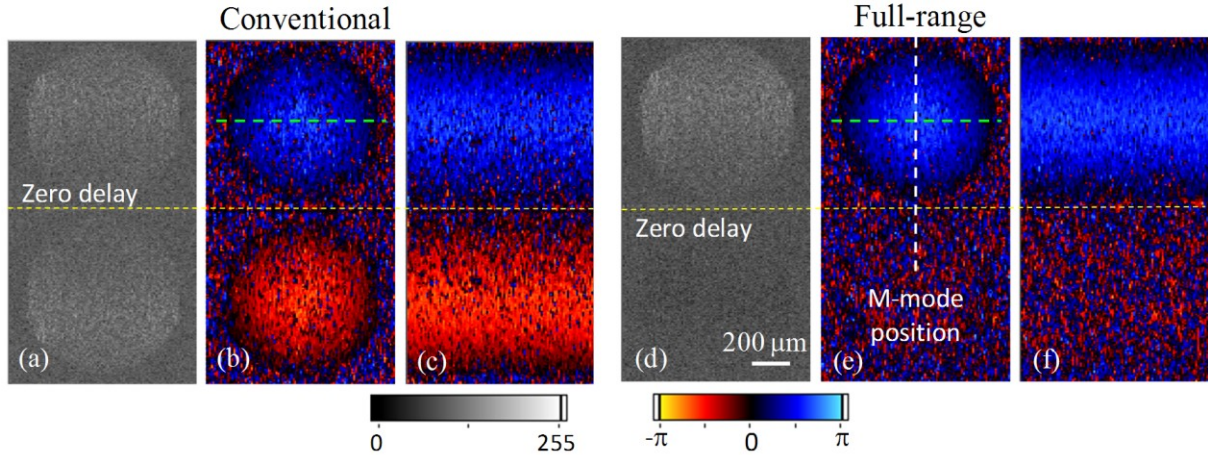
(a) and (d) are intensity images, (b) and (e) are B-mode Doppler images, and (c) and (f) are M-mode Doppler images measured by conventional FD-OCT and DD-FD-OCT, respectively, where the yellow horizontal dash line indicate the zero path delay position, the white vertical dash line indicates the lateral position where the M-mode Doppler was operated, and the white solid line at the bottom right of (d) denotes the scale bar that is applied to all images (a-f).
